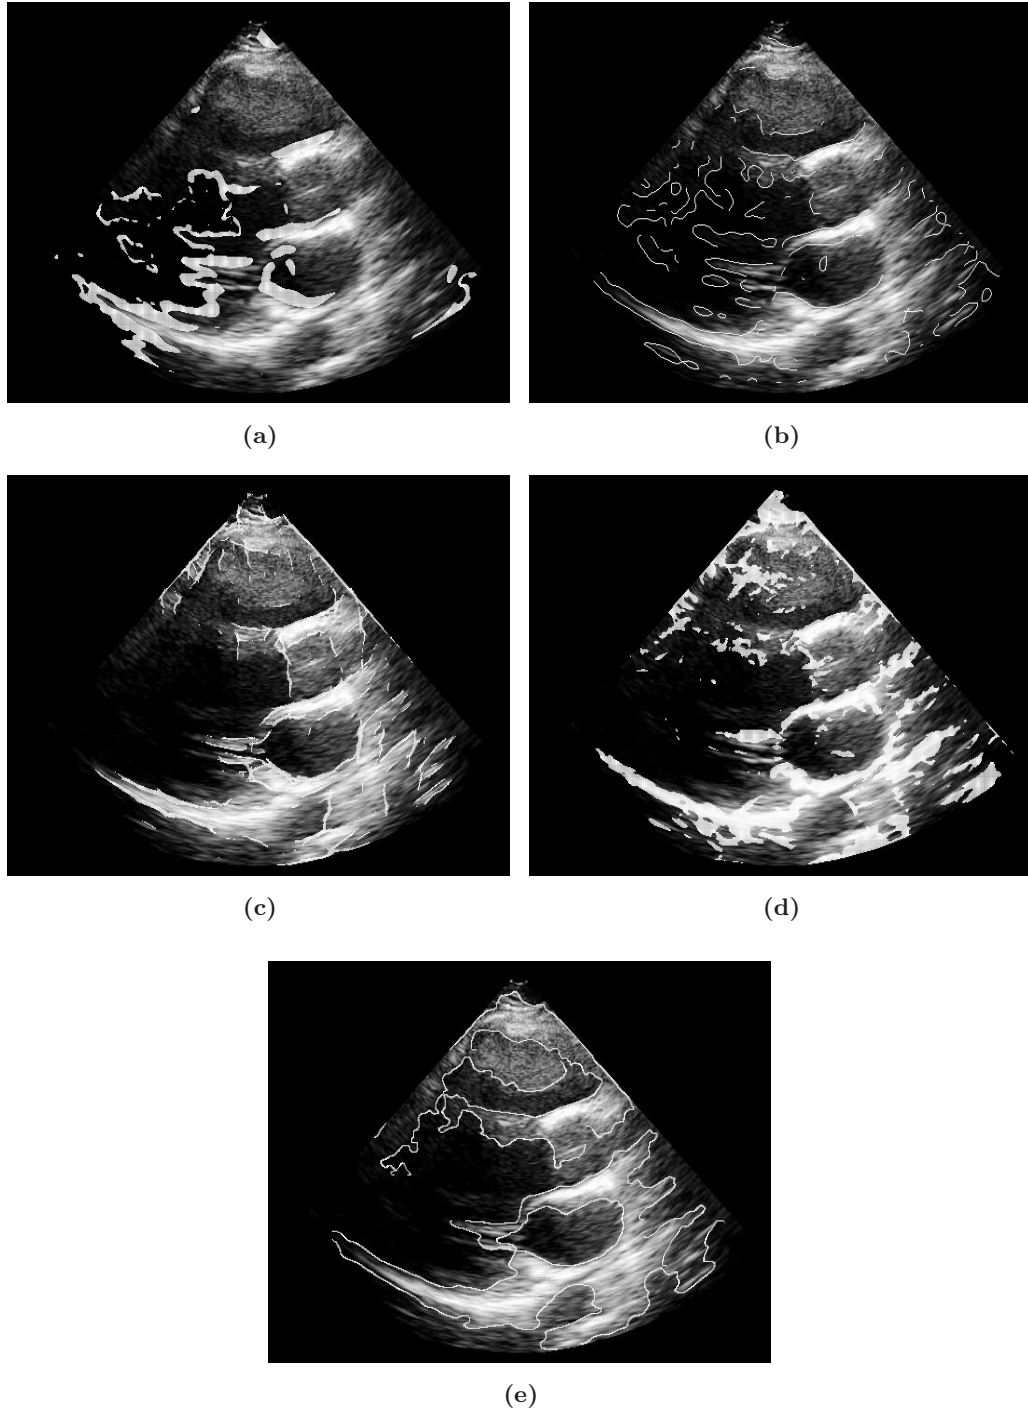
Edge detector output for the clinical ultrasound images of Fig. 6.7(b). (a) CV, (b) RoA, (c) FA, (d) PC, (e) ZC.
